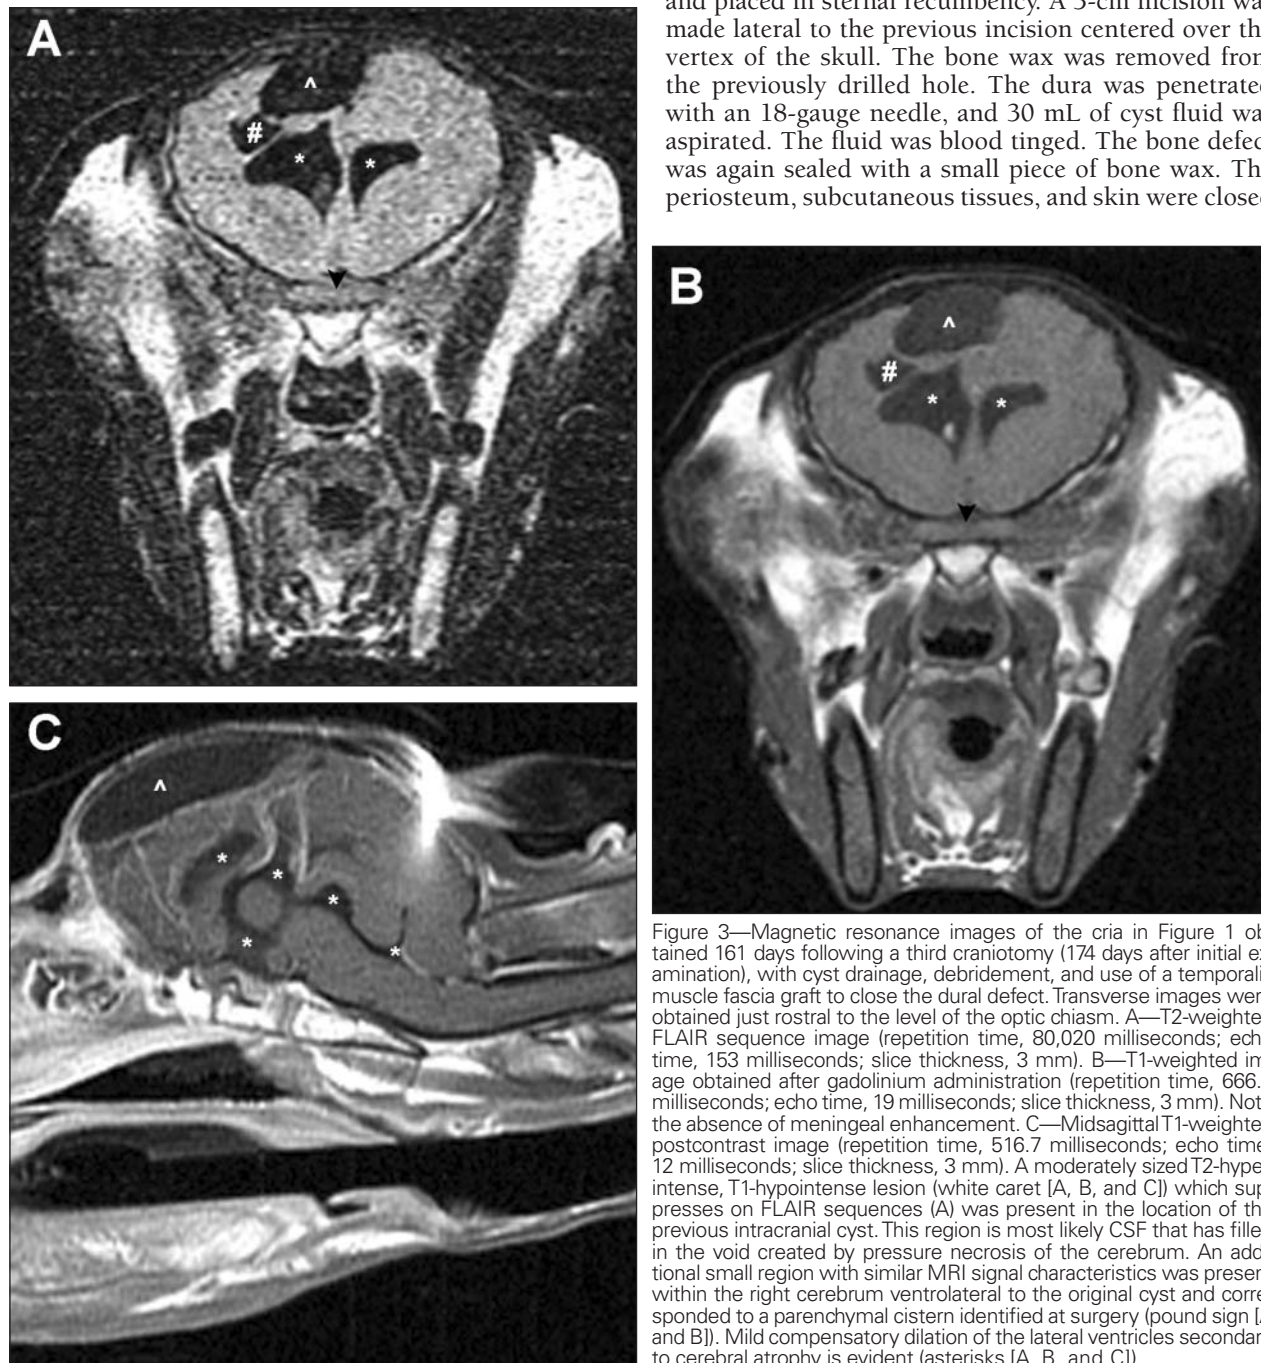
Magnetic resonance images of the cria in Figure 1 obtained 161 days following a third craniotomy (174 days after initial examination), with cyst drainage, debridement, and use of a temporalis muscle fascia graft to close the dural defect. Transverse images were obtained just rostral to the level of the optic chiasm. A—T2-weighted FLAIR sequence image (repetition time, 80,020 milliseconds; echo time, 153 milliseconds; slice thickness, 3 mm). B—T1-weighted image obtained after gadolinium administration (repetition time, 666.7 milliseconds; echo time, 19 milliseconds; slice thickness, 3 mm). Note the absence of meningeal enhancement. C—Midsagittal T1-weighted postcontrast image (repetition time, 516.7 milliseconds; echo time, 12 milliseconds; slice thickness, 3 mm). A moderately sized T2-hyperintense, T1-hypointense lesion (white caret [A, B, and C]) which suppresses on FLAIR sequences (A) was present in the location of the previous intracranial cyst. This region is most likely CSF that has filled in the void created by pressure necrosis of the cerebrum. An additional small region with similar MRI signal characteristics was present within the right cerebrum ventrolateral to the original cyst and corresponded to a parenchymal cystern identified at surgery (pound sign [A and B]). Mild compensatory dilation of the lateral ventricles secondary to cerebral atrophy is evident (asterisks [A, B, and C]).
